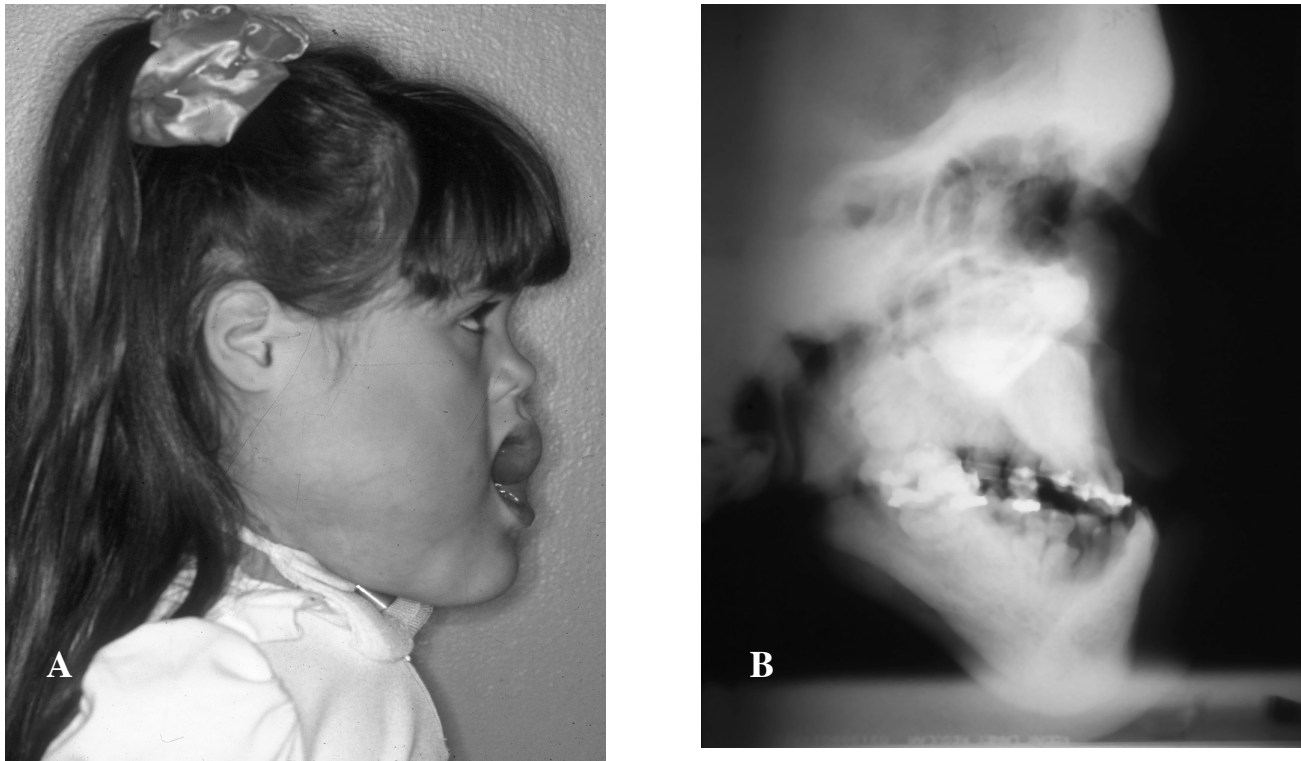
A. Lateral facial photograph, and B. Lateral cephalometric radiograph demonstrating a large cervicofacial lymphatic malformation with associated bony overgrowth.
